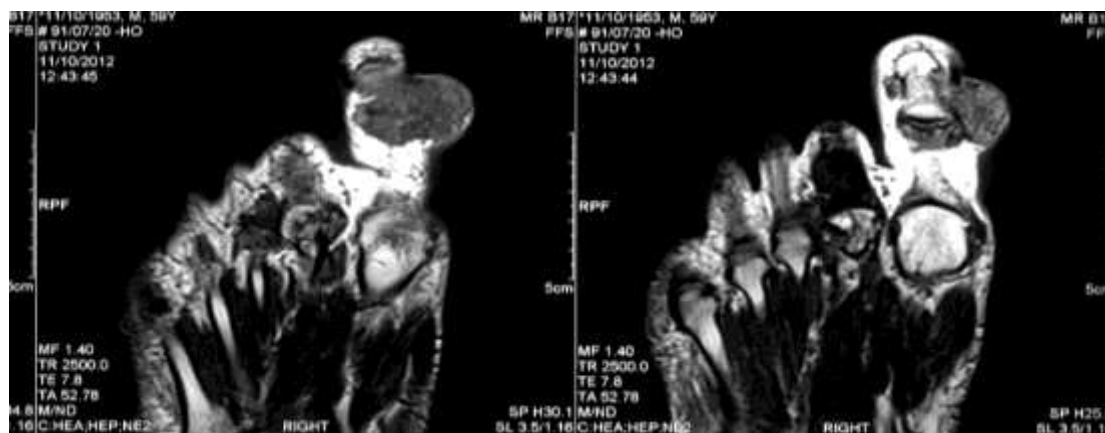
Magnetic resonance imaging (MRI) of right foot
